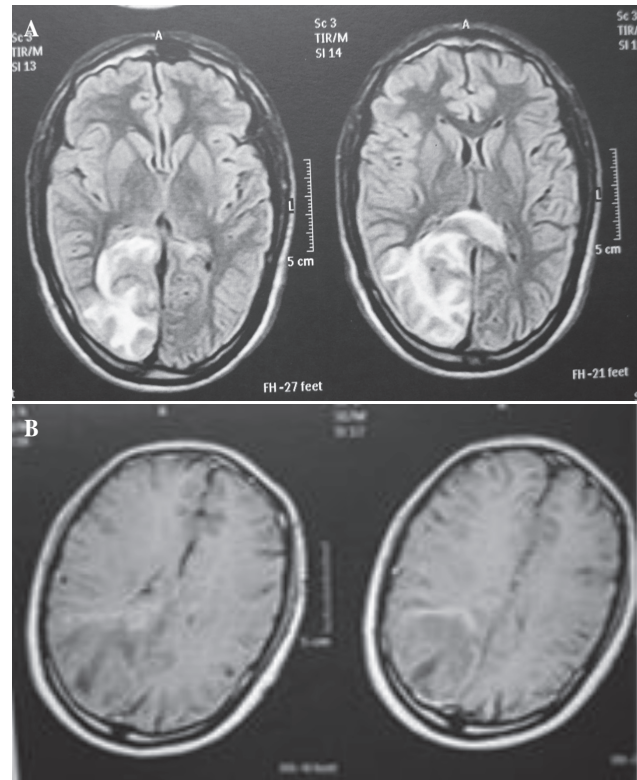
Brain MRI on admission. A: Extensive parenchymal lesion right parietooccipally with inhomogenous signal in T2 and FLAIR sequences and low signal in T1 sequence. Marginal contrast enhancement and extension through the corpus callosum. B: Second little lesion with contrast enhancement in front of the main one. FLAIR = fluid attenuated inversion recovery; MRI = magnetic resonance imaging.
